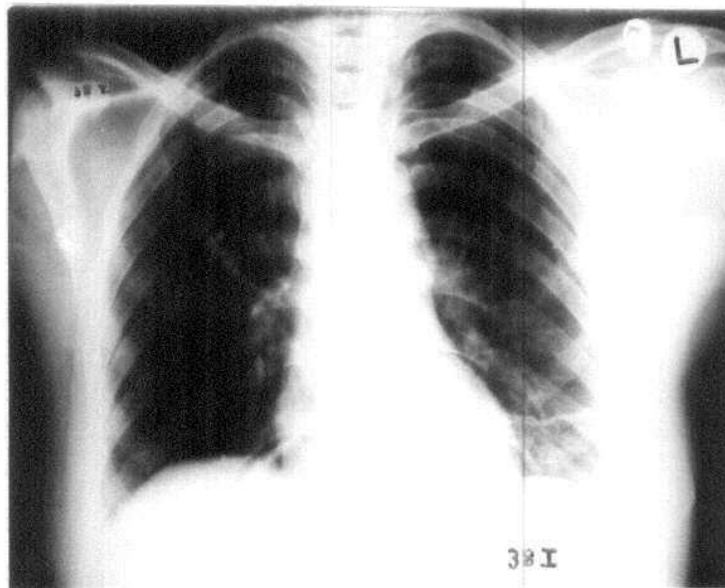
Postoperative chest radiograph for patient No. 38 I (24 hours after surgery): showing Bilateral linear atelectasis (right midzonal and left basal). Left basal diminished aeration.
